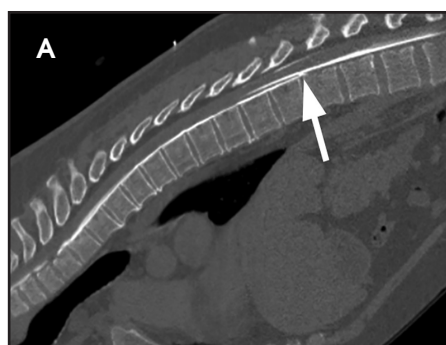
Dynamic CT myelogram with sagittal (A) and axial (B,C) images demonstrating “split” contrast flow (arrow). Subsequent accumulation of contrast in the epidural space (arrowheads). Intradural contrast (curved arrows).
